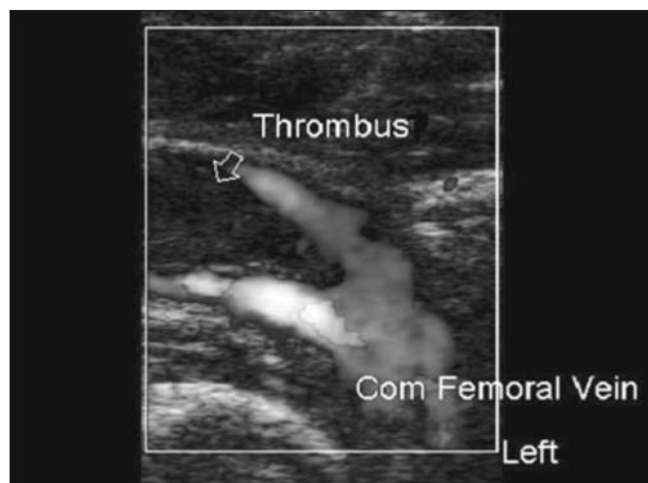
Free-floating thrombus in the common femoral vein on duplex ultrasound examination
